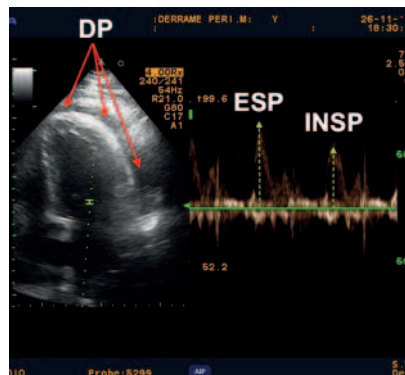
Analysis of mitral flow by pulsed Doppler, showing pericardial effusion in the left image (DP and red arrows) together with the change in transmitral flow with breathing (right), present when hemodynamic compromise exists. Actually this is the pathophysiology of the "paradoxical pulse" in which flow through the mitral valve increases during expiration (ESP) and decreases during inspiration (INSP).
